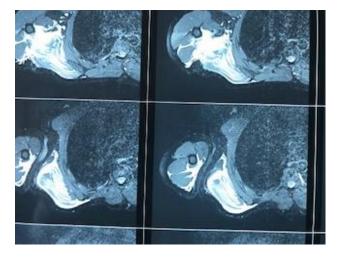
Shoulder MRI scans showing the tear and haematoma.
